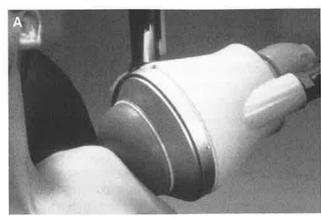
(A) Patient setup for ESWT application using the Storz Minilith SL 1 [27]. (B) Sonogram used in targeting the insertion of the supraspinatus for ESWT - supraspinatus tendon (S), greater tuberosity (T) [27].
